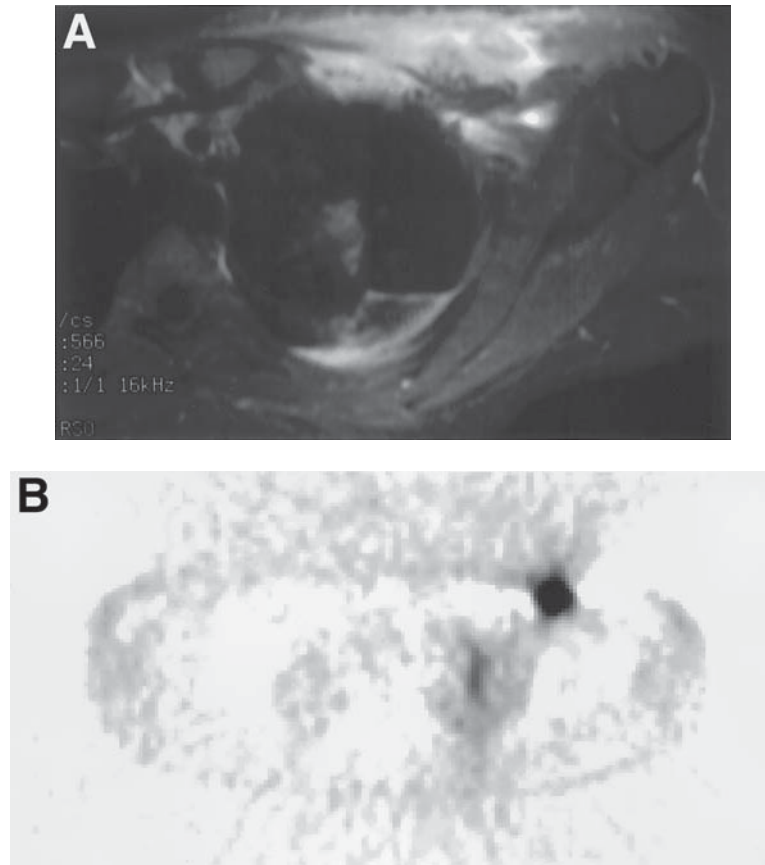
(A) Axial T2-weighted MRI with fat saturation in 34-yr-old woman previously treated with radiation for metastatic involvement of the left brachial plexus. Diffuse increased T2 signal in the irradiated tissue makes it difficult to distinguish posttreatment changes from recurrent disease. (B) Transverse image from FDG PET study clearly shows markedly elevated FDG uptake in the brachial plexus indicative of active tumor.
